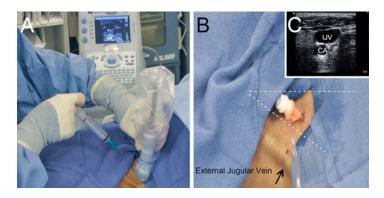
Jugular vein access. We routinely use real-time ultrasound guidance to locate the jugular vein (a). The sheath should be inserted through the apical portion of the triangle bounded by the medial and lateral heads of sternomastoid and the clavicle. In (b), the dotted lines indicate the heads of sternomastoid. Note the close proximity of the internal jugular vein (IJV) to the carotid artery (CA), which usually lies medial and deep to the vein (c)
